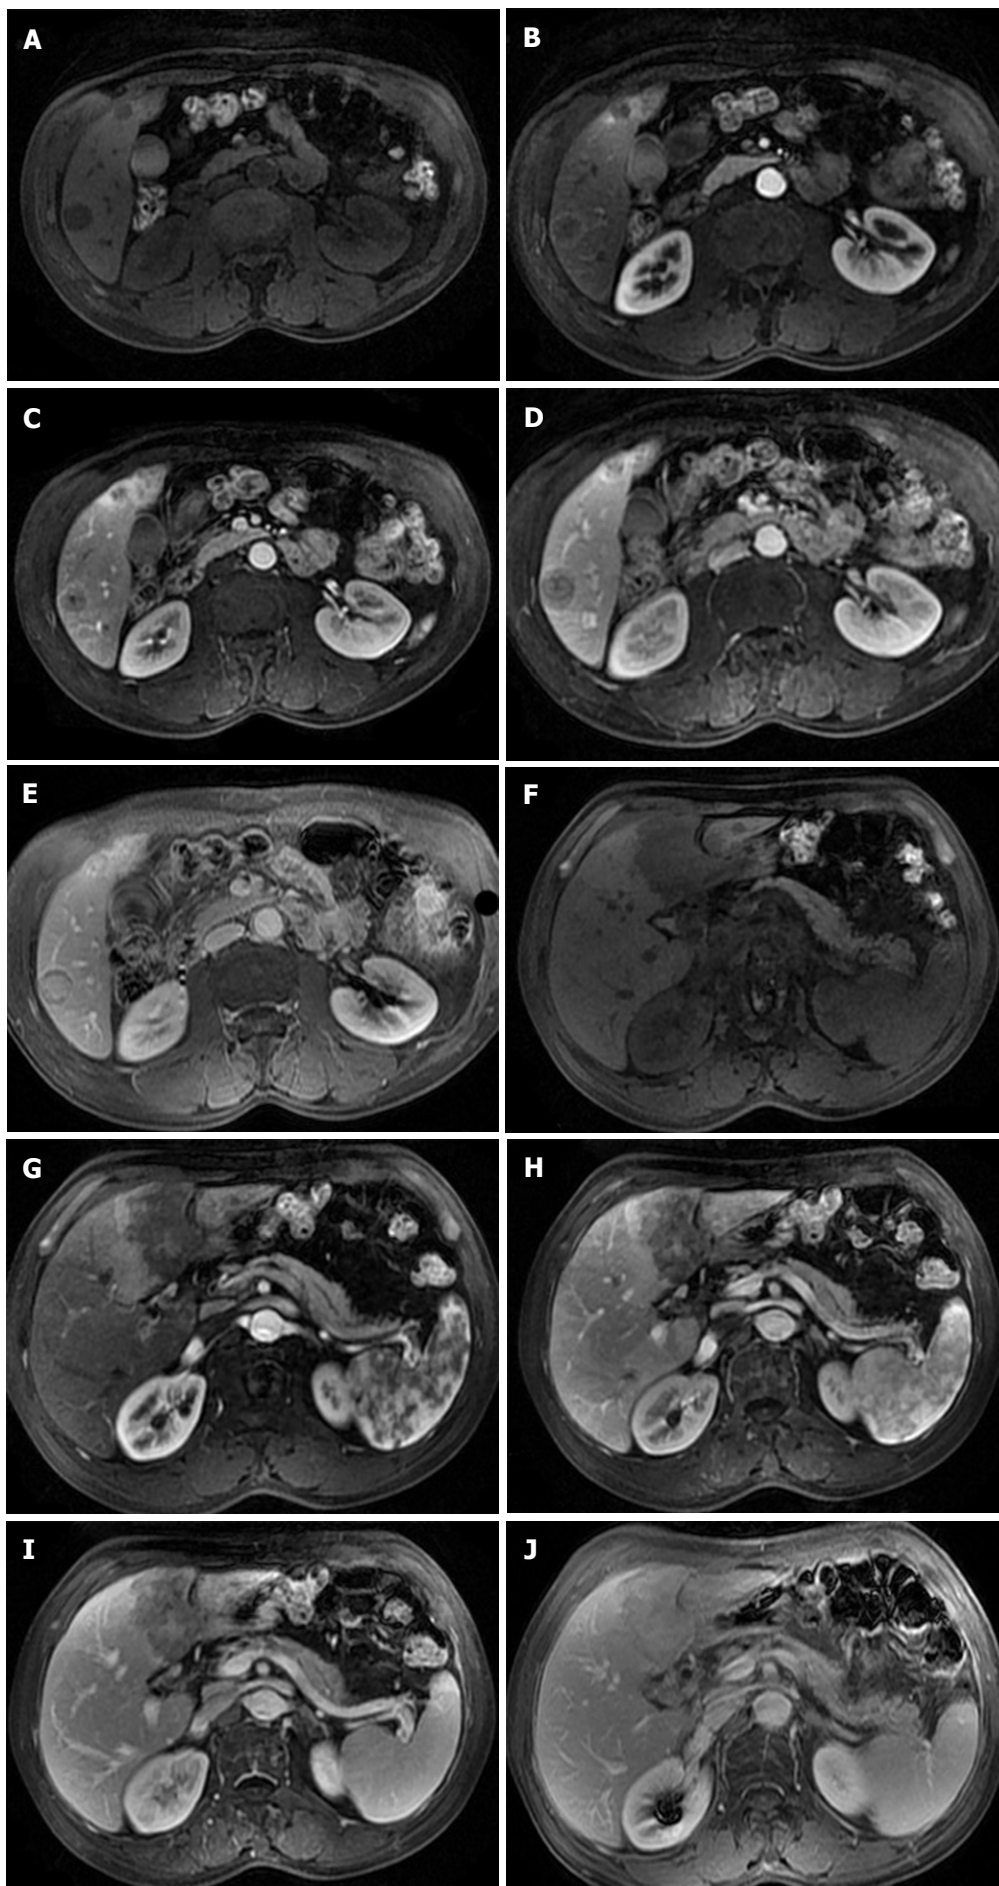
Multifocal hepatic epithelioid hemangioendothelioma in a 60-year-old man. Contrast-enhanced multiple-phase magnetic resonance imaging shows a progressive-enhancement target sign in the lesions in segment VI of the liver (A-E) and lamellar lesions with progressive enhancement in the left lobe of the liver (F-J).
